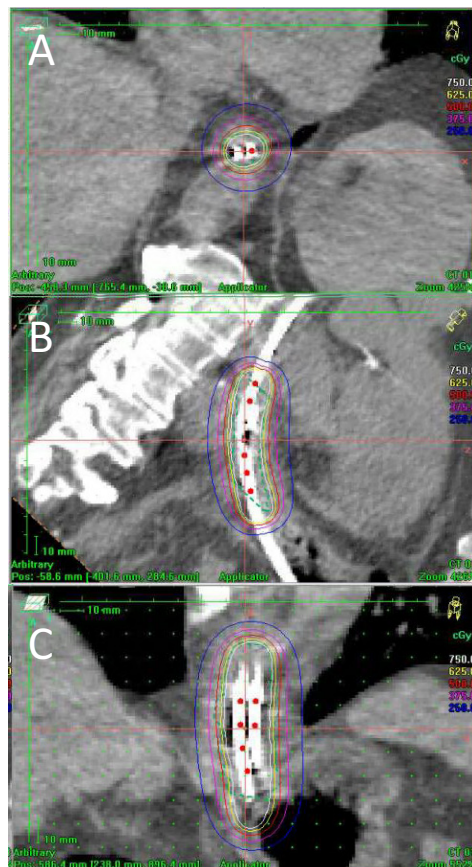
Axial (A), sagittal (B), and coronal (C) CT treatment planning images for a patient with a locally advanced esophageal cancer undergoing HDR brachytherapy. Two transesophageal tubes (each 1.0 meter length) were used to deliver a dose of 5 Gy
